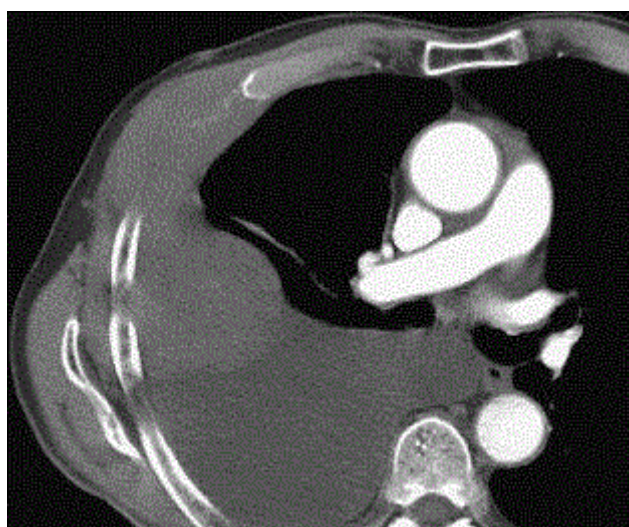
CT scan image showing mesothelioma eroding through the chest wall.
